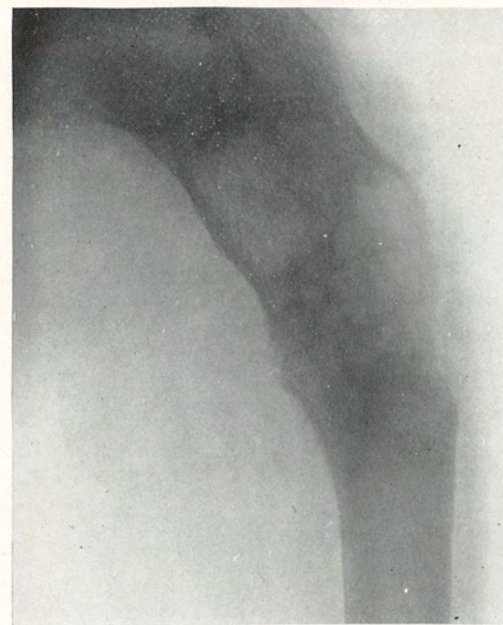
Radiograph in second case, male aged fourteen. One month after operation. Cavity filled with clot. Shows union of fracture and beginning obliteration of cysts. Shows other cysts.
